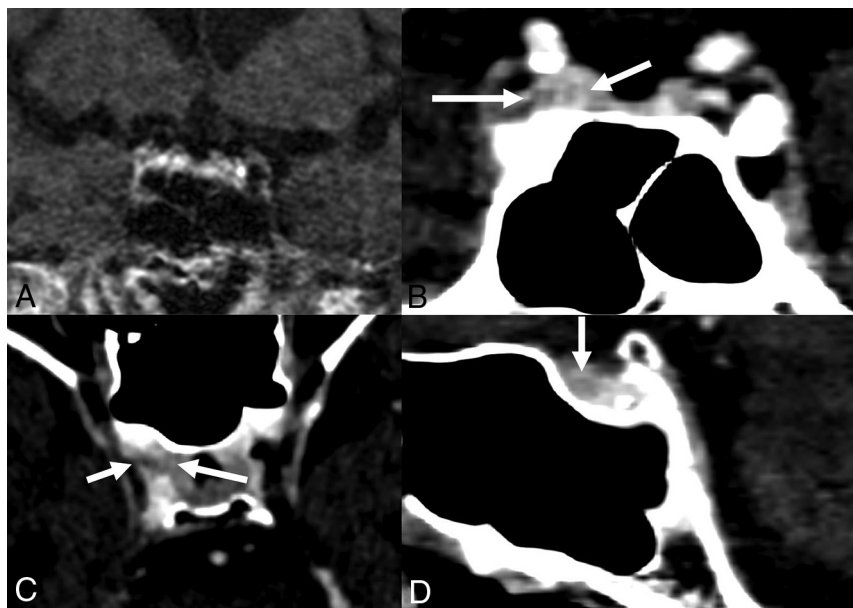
Patient 3, a 68-year-old man with Cushing disease. His preoperative MR imaging (A) was nondiagnostic secondary to motion. Coronal (B), axial (C), and sagittal (D) images from the fourth sequence of a dynamic contrast-enhanced PCD-CT show a hypo-enhancing lesion (arrows) in the right aspect of the pituitary gland, which involves the cavernous sinus. This was a pathology-proven adenoma.
